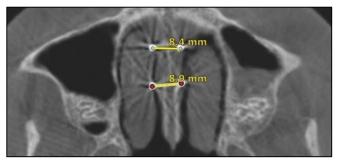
"P12" and "P34" parameters: CBCT image in the axial plane.
